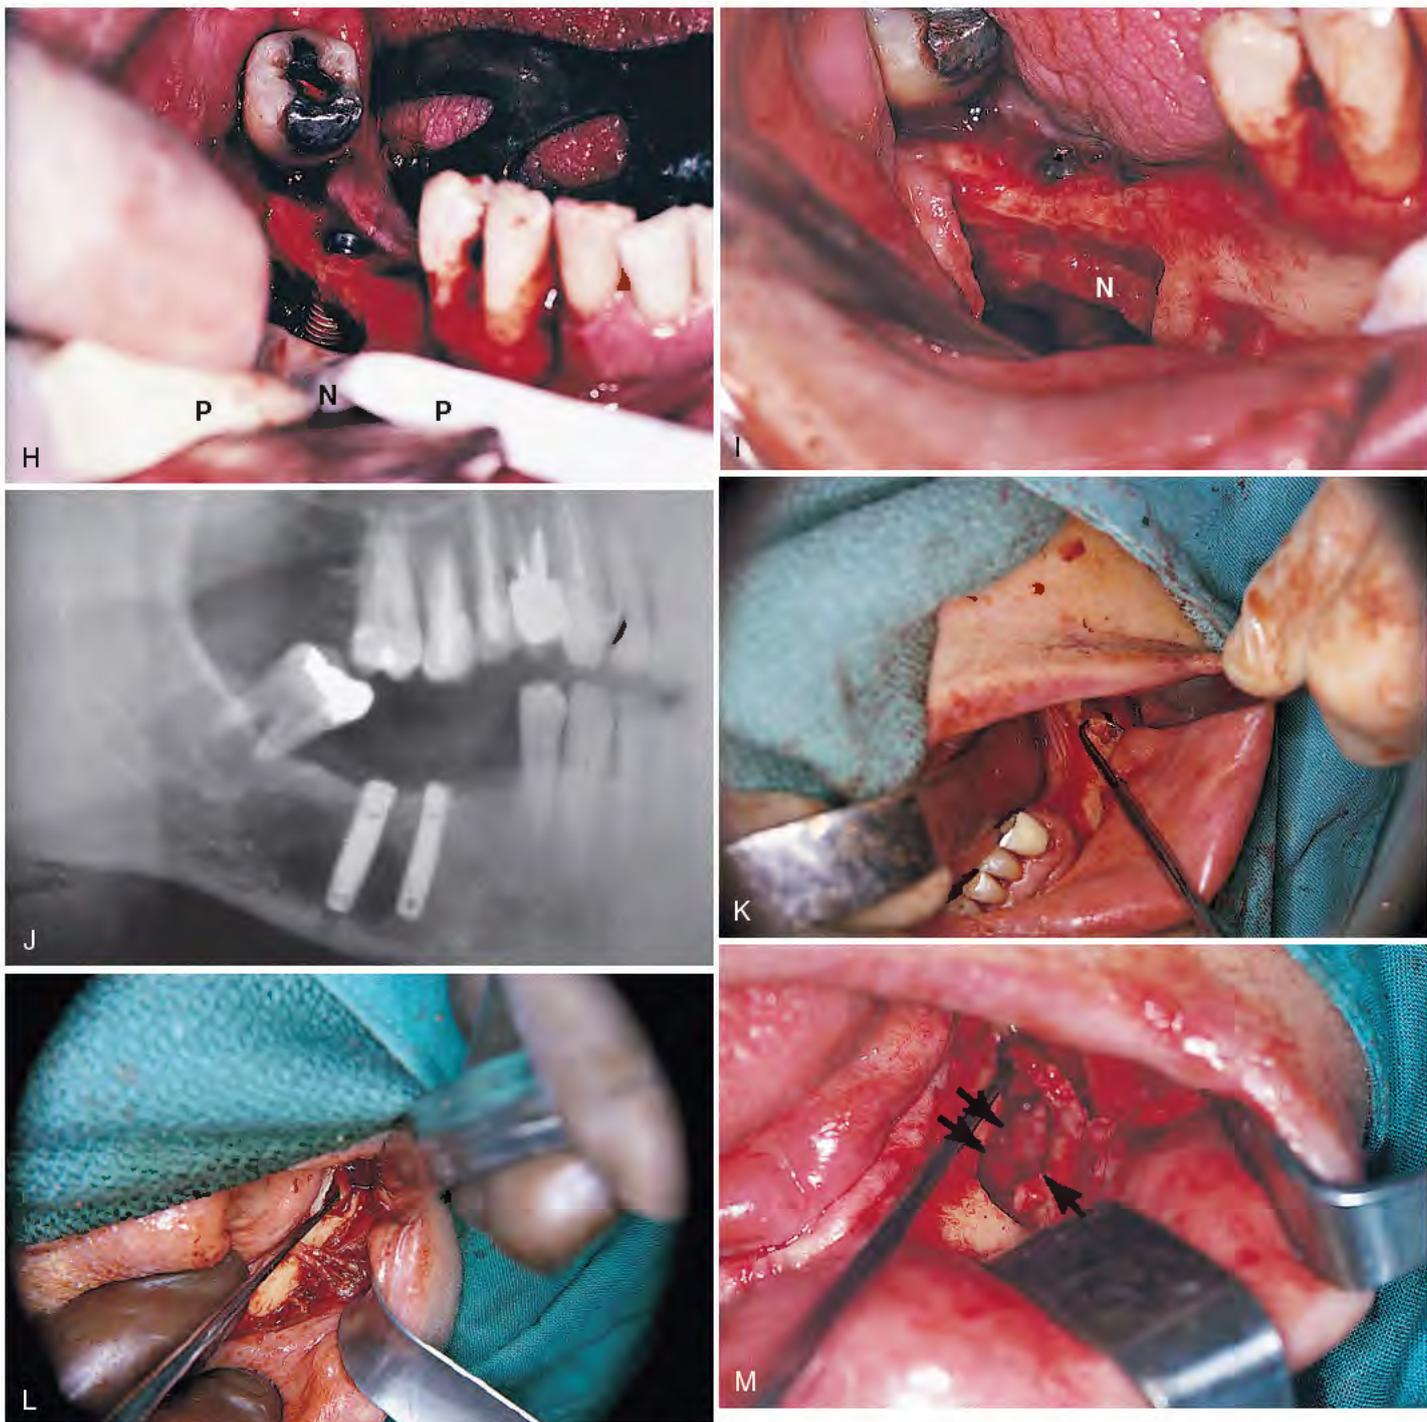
cont'd. H, With the neurovascular bundle (*N*) retracted by the Penrose drain (*P*), these Steri-Oss implants are placed almost to the inferior border of the mandible. I, After the requisite Colla-Cote has been placed to cushion the implant infrastructures, the neurovascular bundle is gently replaced; it is insulated with a moistened collagen sheet, and the wound is closed. J, The postoperative radiograph shows the extent to which an altered mandible may be used. K, As an alternative to removing the mandibular neurovascular bundle from the canal alone, which sometimes is physically restrictive, a mentomandibular bundle continuum may be mobilized. This is done by exposing the mental foramen and using it as a guide to locate and expose the contents of the canal. L, The round bur is used first, followed by the round diamond to extend the initial osteotomy anteriorly until the posterior osseous rim of the mental foramen is picked and curetted away. M, When the distal half of the foramen (*arrows*) and its canal are removed, the contiguous defects thus created allow comfortable retraction of the mentomandibular bundle, giving wider access to the potential implant host site.
